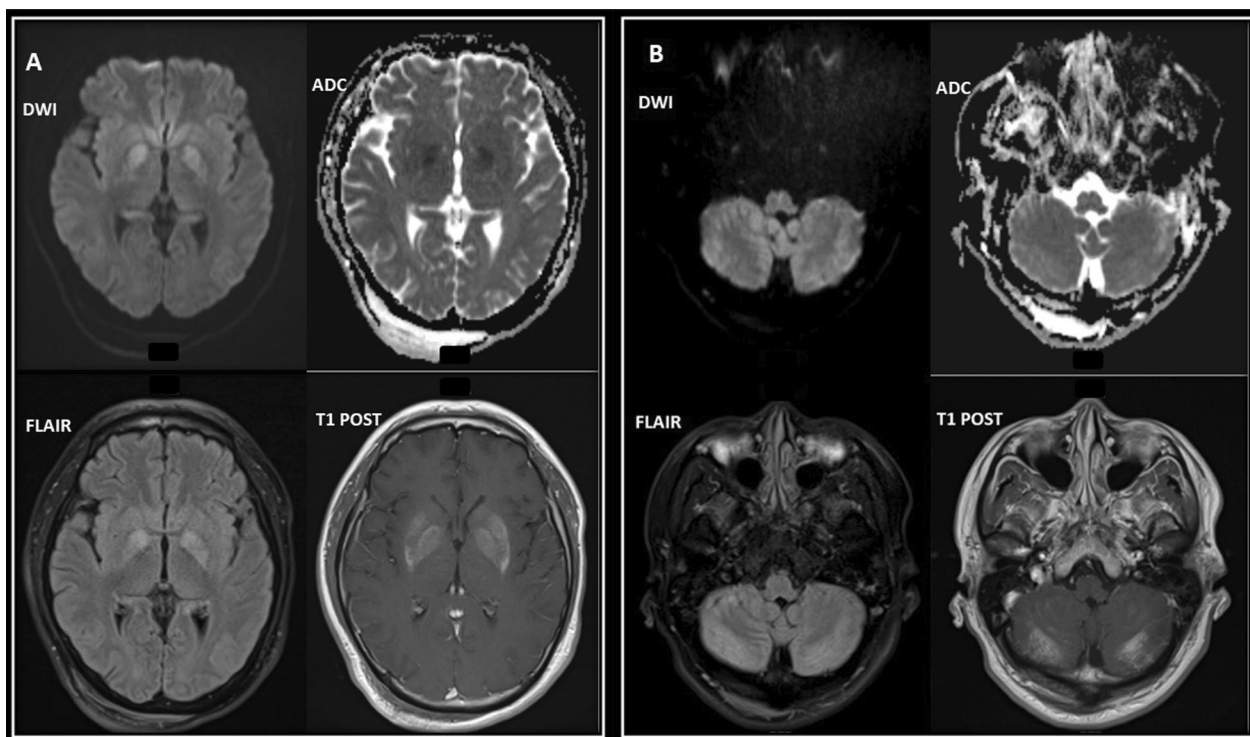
MRI characteristics of paraneoplastic limbic encephalitis. MRI brain showing uniform bilateral symmetric restricted diffusion, hyperintensity and avid post-contrast enhancement involving the bilateral caudate (A), globus pallidus (A), and cerebellum (B) (DWI diffusion-weighted imaging, ADC apparent diffusion coefficient, FLAIR fluid-attenuated inversion recovery). Mild right posterior scalp edema noted here is thought to be related to self-injurious behavior as it resolves in subsequent MRIs and is not commented on by reading radiologist
